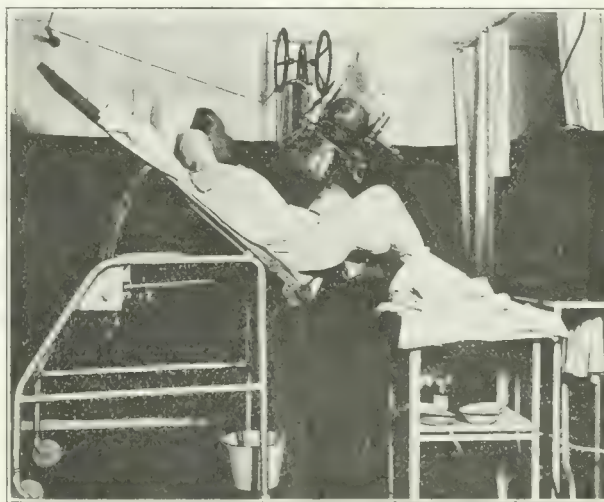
Cystoscopic table showing its use in one of the many positions with the x ray apparatus in place for radiographic work.
